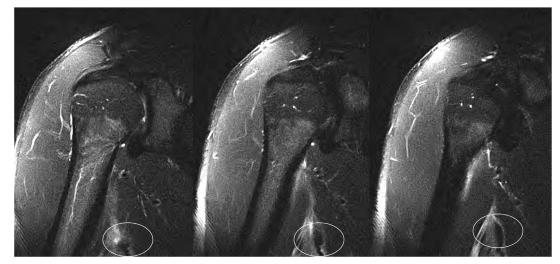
Coronal cuts of the shoulder MRI, revealing a retracted LDT tear, circled in white. (LDT, latissimus dorsi tendon; MRI, magnetic resonance imaging.)
